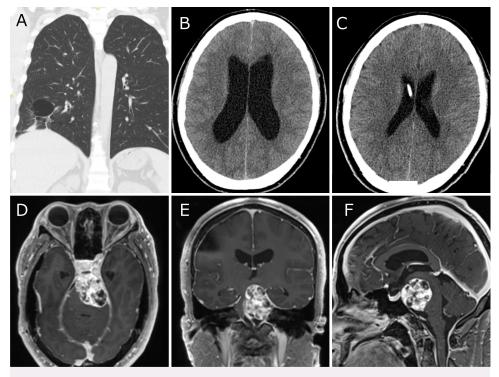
Clinical course after oral osimertinib administration. A: The lung lesions shrank after 6 months of osimertinib, as shown on the coronal chest CT scan. B: The intracranial lesion increased in diameter and caused obstructive hydrocephalus. C: A ventriculoperitoneal shunt was placed for the treatment of hydrocephalus. D–F: The brain tumor continued to increase in size and compressed the brainstem.
